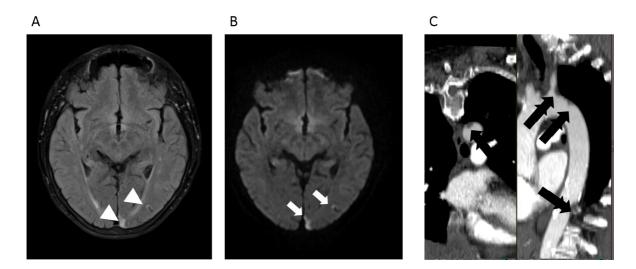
Thromboembolic manifestations in patient 2. (A) MRI showed cortical lesions in FLAIR (white arrowheads). (B) Diffusion weighted imaging confirmed cortical ischemia of embolic origin (white arrows). (C) Arterial phase of lung CT depicted multiple thrombi in the aorta and at the origin of the left common carotid artery (black double arrows).
